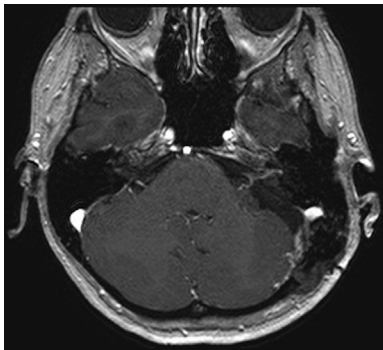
Postoperative magnetic resonance imaging confirming gross total resection of the intracanalicular vestibular schwannoma.
